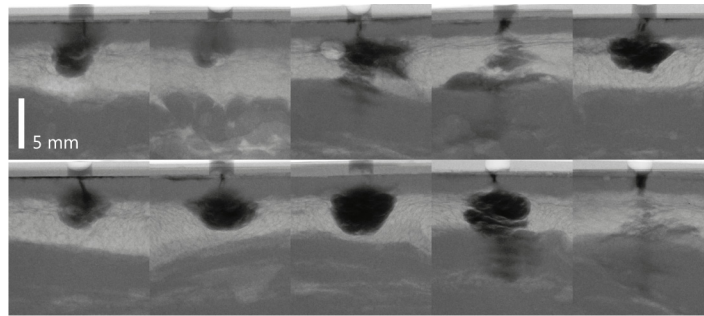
Post-injection X-ray images of skin, fat, and muscle samples. Trials 1 through 10 are arranged left to right, top to bottom.
